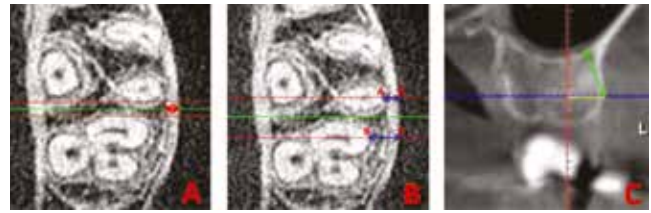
CBCT measurements: A, axial view, buccal cortical bone thickness (red arrow); B, axial view, buccal plate thickness at distobuccal root of first maxillary molar and mesiobuccal root of second maxillary molar (blue arrow); C, coronal view, IZ crest thickness (or biting depth for MI implant) (green arrow).
